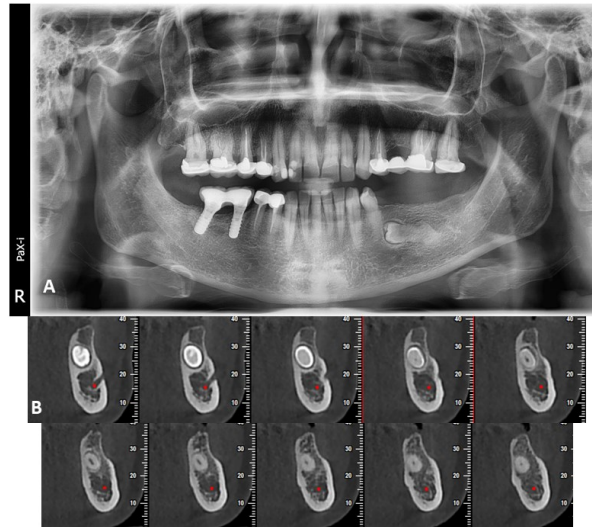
Pre-operative radiographic view: (A) orthopantomogram showing the maxillofacial complex, (B) cross sectional view of the cone beam computed tomography showing the premolar and its relation with the surrounding anatomical structures
